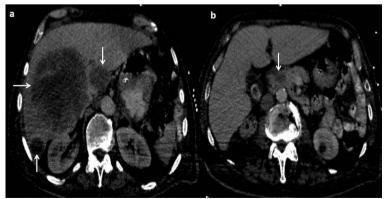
Abdominal CT showing three metastatic lesions in the liver (a, white arrows), and a lesion of a cystic nature in the head of the pancreas (b, white arrow).
